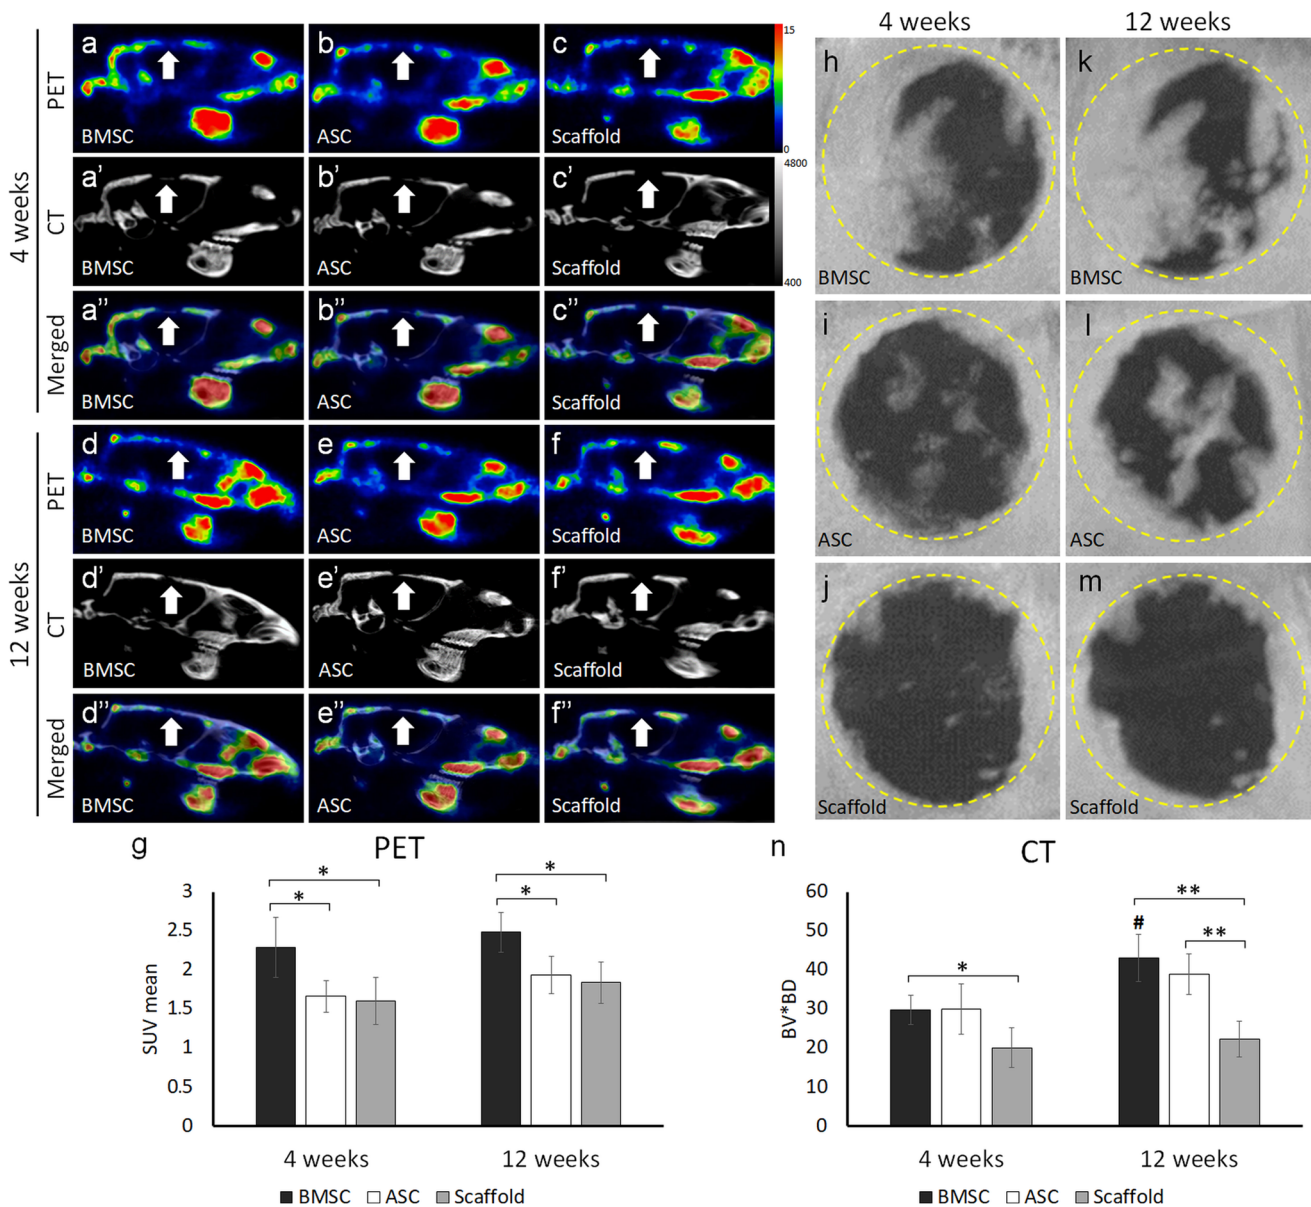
Osteogenic cellular activity and bone formation in defects with scaffold/BMSC, scaffold/ASC, and scaffold without cells after in vivo implantation for 4 and 12 weeks. a–f Representative images of sagittal sections from the PET/CT scanning. White arrows indicate defect area. g Quantitative graph based on the PET data. h–m Representative CT scanning images showing bone formation in the defects. n
